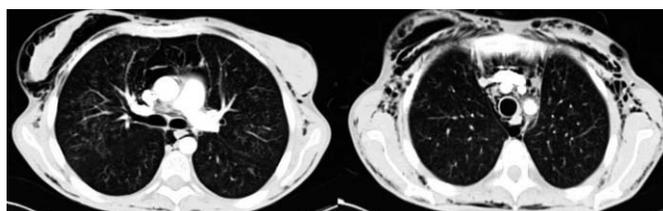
Computed tomographic scan showing extensive subcutaneous emphysema and pneumomediastinum without pneumothorax, in addition to significant bronchiectasias with marked thickening of the bronchial walls and an alveolar-interstitial pattern with a patchy ground-glass appearance.
